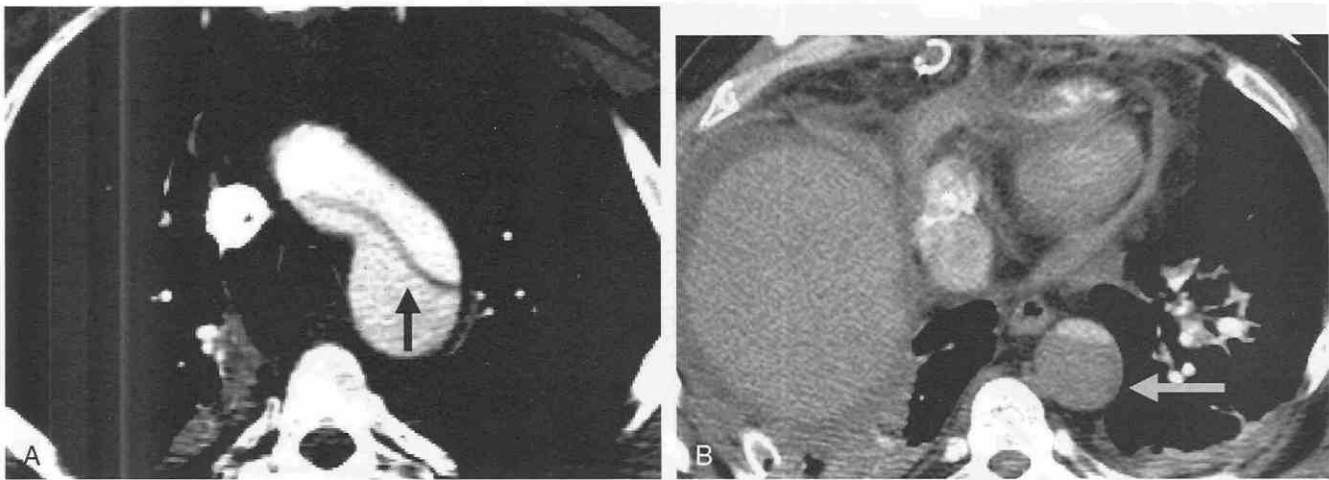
A, Axial multislice CT scan shows an aortic dissection flap involving the aortic arch (arrow). B, Axial scan at the level of the descending aorta shows faint opacification of the anteriorly compressed true lumen. The early injection results in inadequate visualization of the false lumen.
